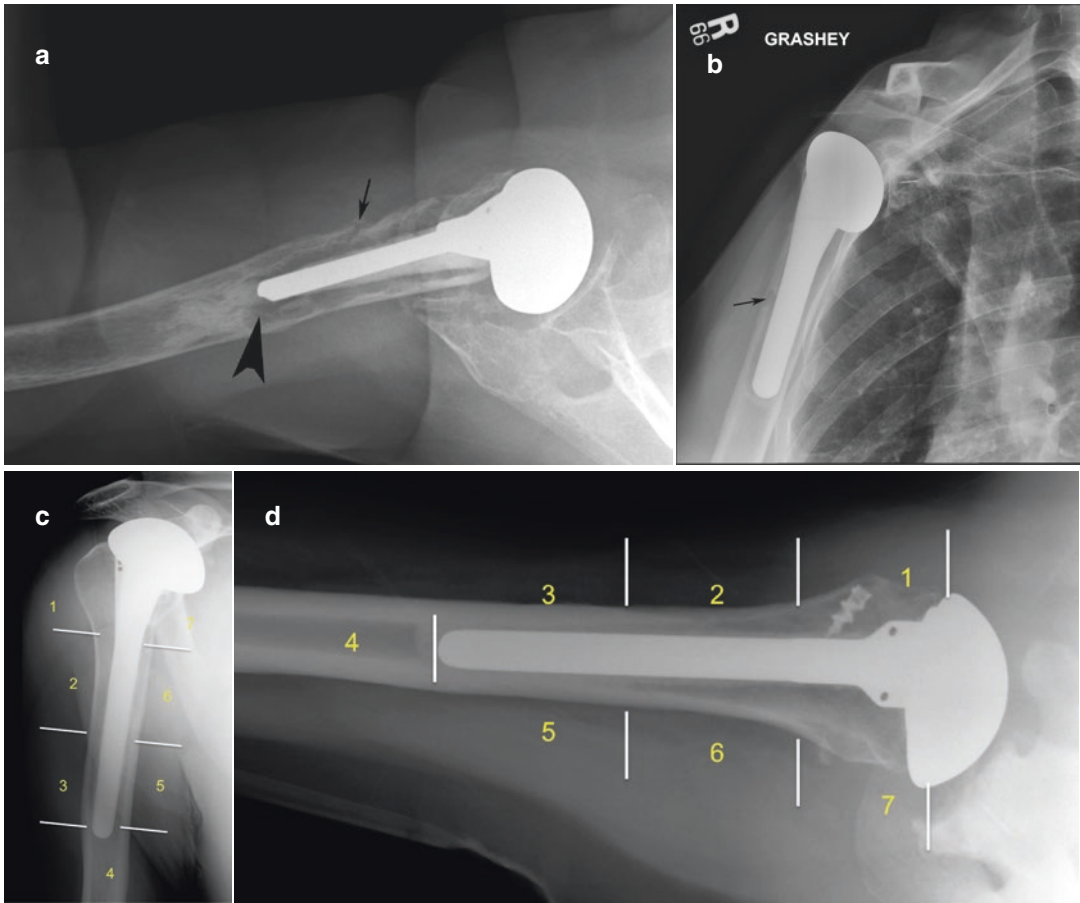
Humeral component radiolucency. (a) Lateral radiograph of a right shoulder hemiarthroplasty shows radiolucency greater than 2 mm (arrowhead) around the humeral component and small anterior periprosthetic fracture (arrow) through an area of radiolucency. (b) Grashey radiograph of a right ATSA shows focal osteolysis (arrow). (c) AP and (d) lateral radiographs show eight humeral component and small anterior periprosthetic fracture (arrow) through an area of radiolucency. (b) Grashey radiograph of a right ATSA shows focal osteolysis (arrow). (c) AP and (d) lateral radiographs show eight zones of radiolucency according to Gruen classification
